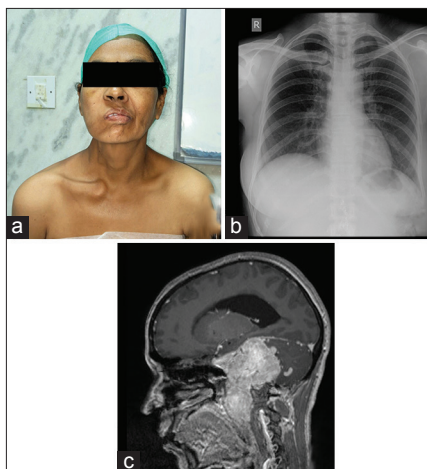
(a) Clinical photograph revealing anterior sternoclavicular dislocation on the right. (b) Chest radiograph showing an increase in sternoclavicular joint space with dislocation on right. (c) Magnetic resonance imaging showing large craniocervical glomus jugulare tumor
